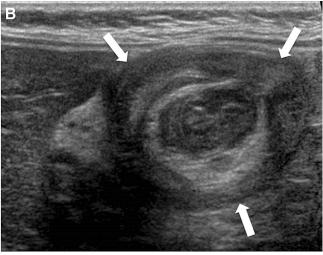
Left lateral decubitus radiograph in a young child (A) who presented with abdominal pain demonstrates a round soft tissue density mass (*asterisk*) outlined by gas within the right hemiabdomen. Longitudinal ultrasound image of the right
